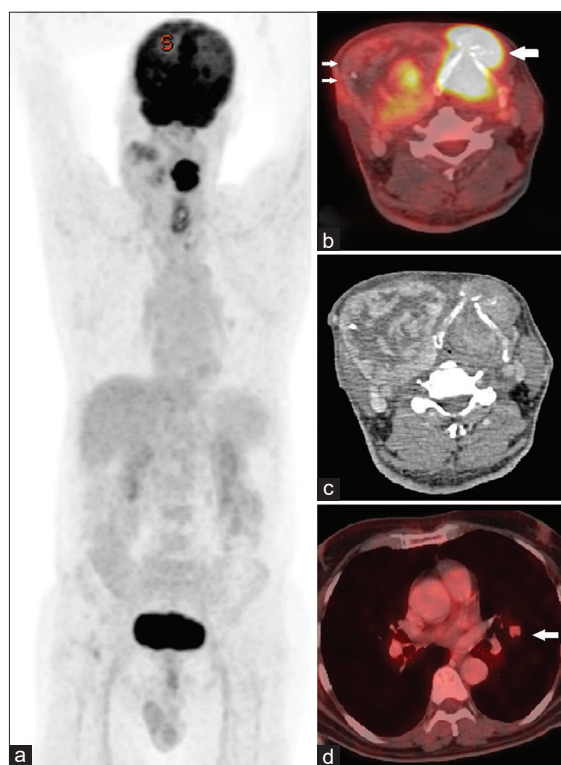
(a) Maximum intensity projection image - increased fluorodeoxyglucose avidity in the midline of the neck. (b) Fused axial image - markedly increased metabolic activity in left-sided mass lesion (large single arrow). Another large solid-cystic mass lesion arising from the right lobe of the thyroid gland with mildly increased fluorodeoxyglucose uptake (small double arrow). (c) Axial computed tomography scan of the neck - left-sided mass lesion is not separable from the isthmus of the thyroid, thyroid cartilage, and obstructing the supraglottic larynx. (d) Small soft-tissue parenchymal nodules in the lingular segment of the left lung with minimally increased metabolic activity
